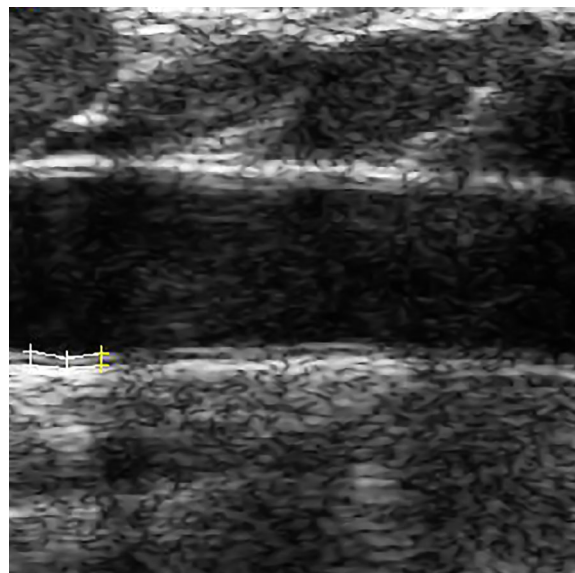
Image from a typical, normal CIMT ultrasound test of the right common carotid artery. *Central area* shows the arterial lumen; *crosses (lower left)* indicate computerised measurement of CIMT. *CIMT* carotid intima-media thickness
